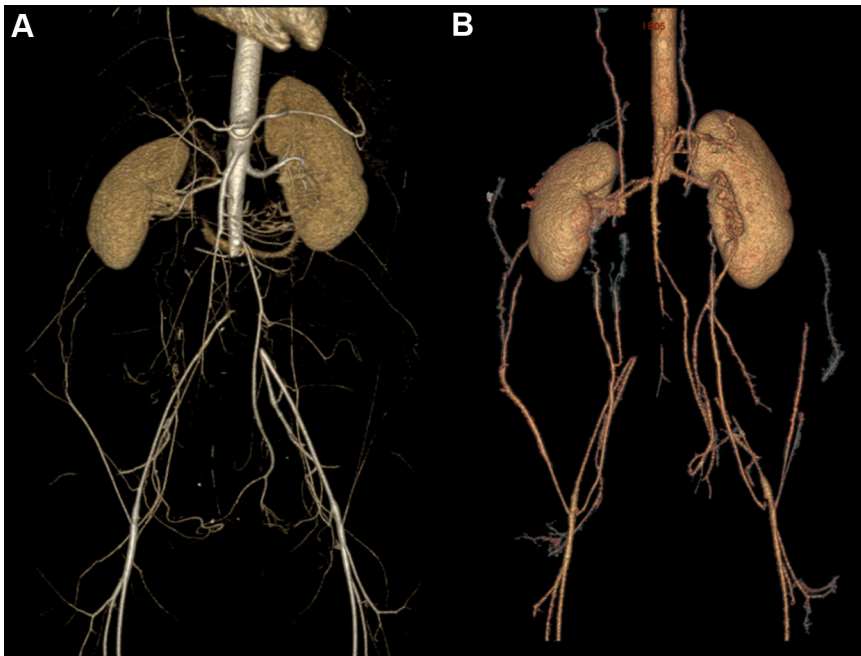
(A) CT scan performed on May 2012 demonstrating the distal abdominal aorta occlusion starting below the inferior mesenteric artery and extending to
